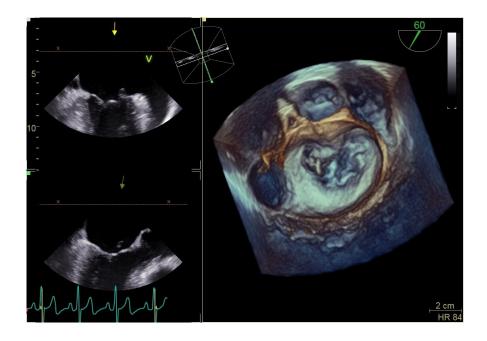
Trans-esophageal-echocardiography with three-dimensional reconstruction (right) showing an isolated prolapse of the P1 segment of the mitral valve
